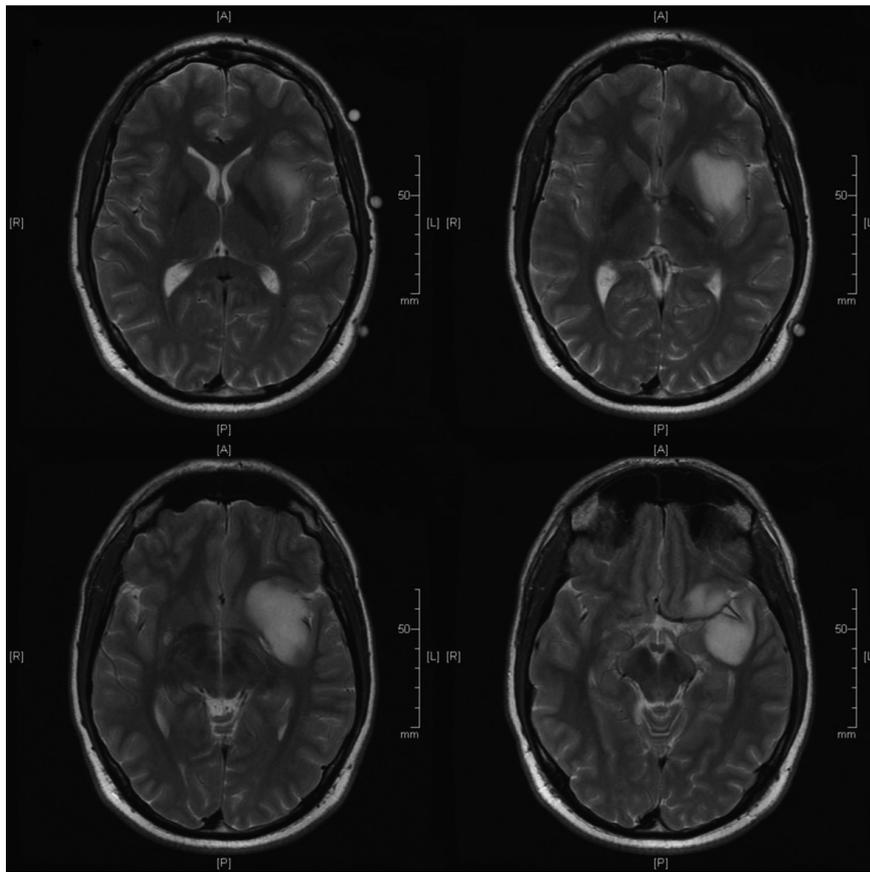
Preoperative transaxial T1-weighted MR images showing a left frontotemporal low-grade astrocytoma, which involved the insula, temporal stem, and orbitofrontal cortex. A: anterior, P: posterior, R: right, L: left.
